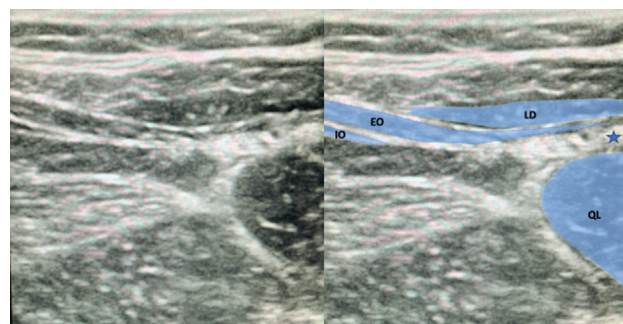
Ultrasound image of the anatomical structures and local anesthetic injection point for posterior QLB. Abbreviations: EO, external oblique muscle; IO, internal oblique muscle; LD, latissimus dorsi muscle; QL, quadratus lumborum muscle. Note: *Injection point.
